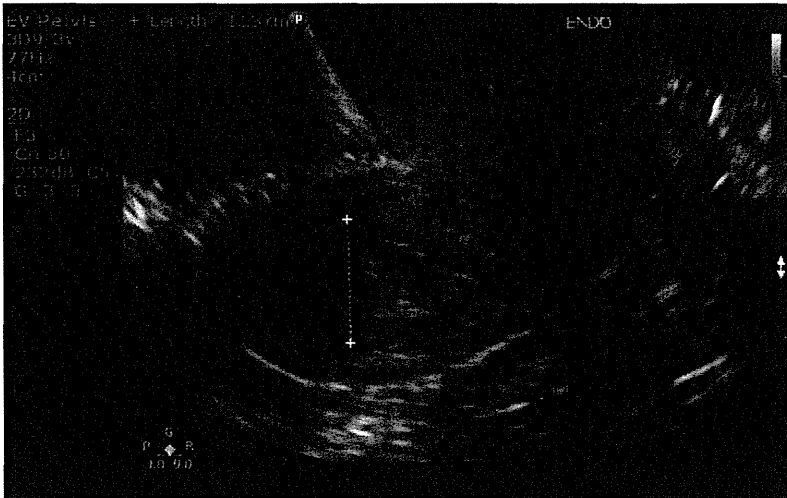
Transvaginal ultrasound of the uterus
